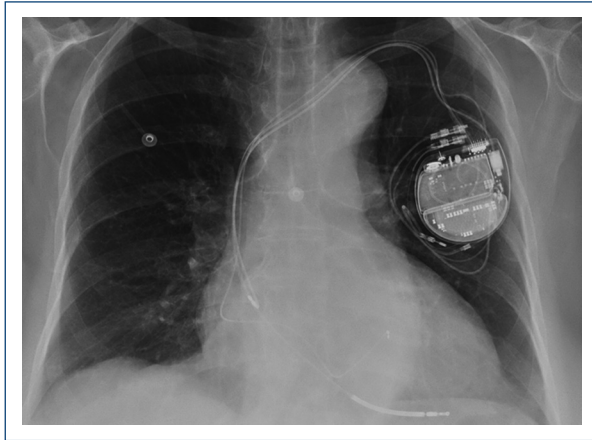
Chest radiography after implantation of ICD.
